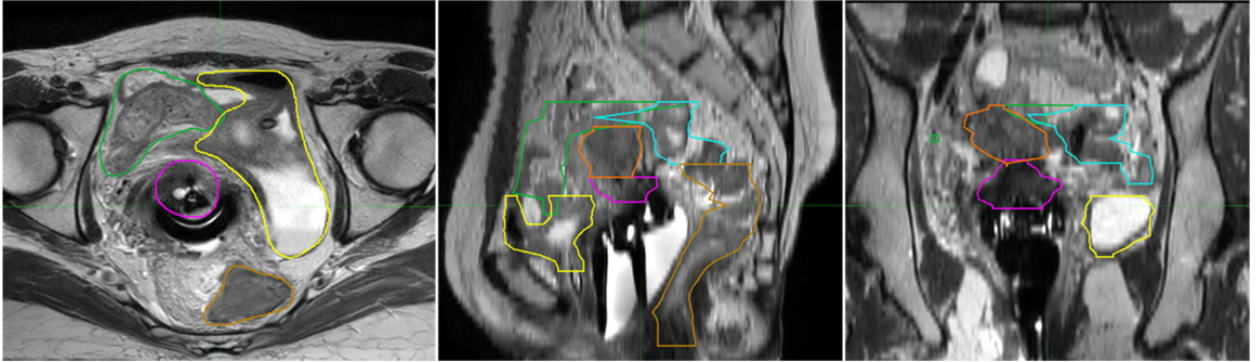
Image segmentation on MRI for a GYN brachytherapy patient, showing axial, sagittal, and coronal views. The segmented structures are indicated by different colors: magenta for the cervix, yellow for the bladder, green for the bowel, orange for the uterus, gold for the rectum, and blue for the recto sigmoid.
